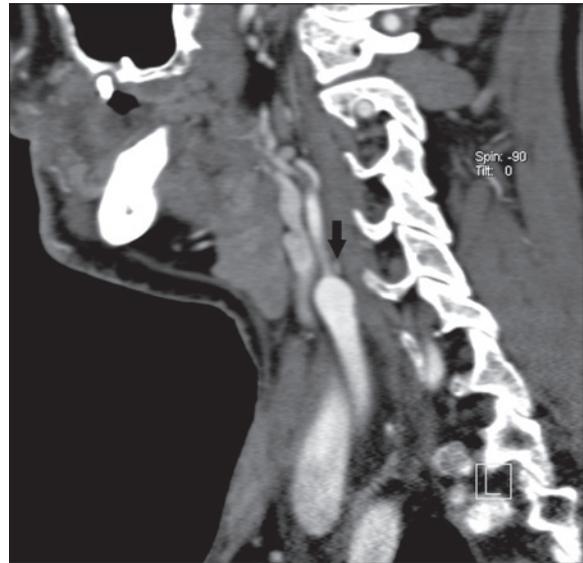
CTA examination of the carotid arteries. Sagittal projection. Modified protocol – beginning of acquisition: 90s from the moment of administering intravenous contrast agent.
